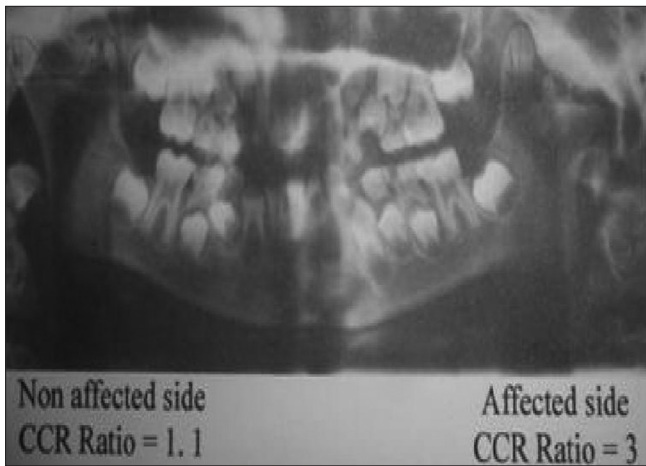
Assessment of coronoid enlargement on orthopantomogram
